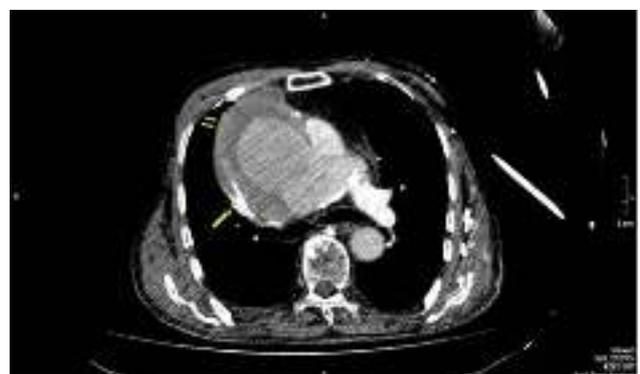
Axial contrast enhanced CT: Huge saccular aortic aneurysm (double arrows) obliterating superior vena cava (large arrow)
